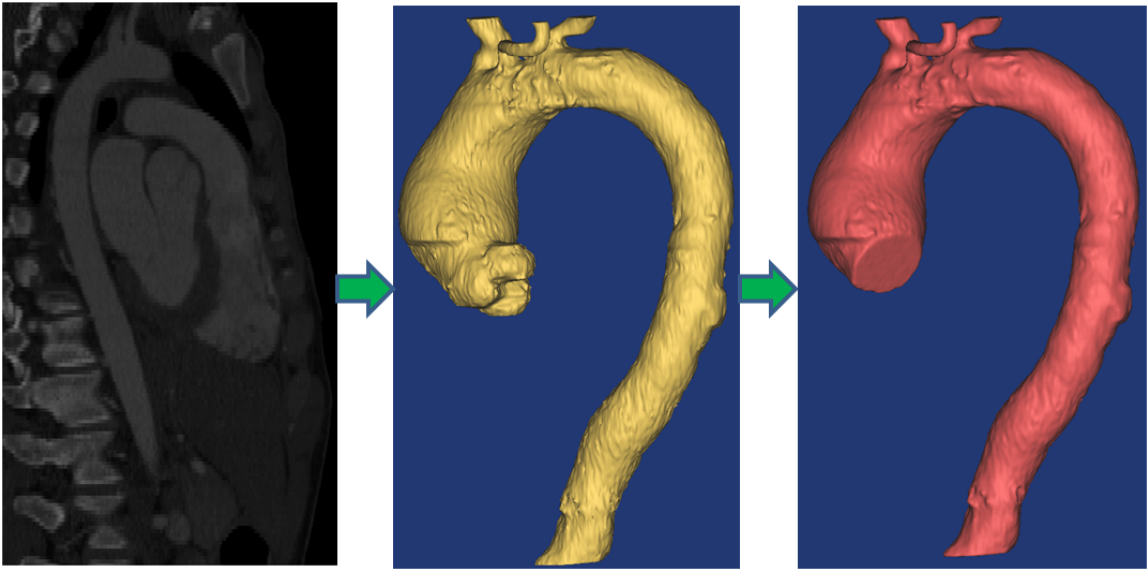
Evolution of Diseased aorta from CT dicom data
